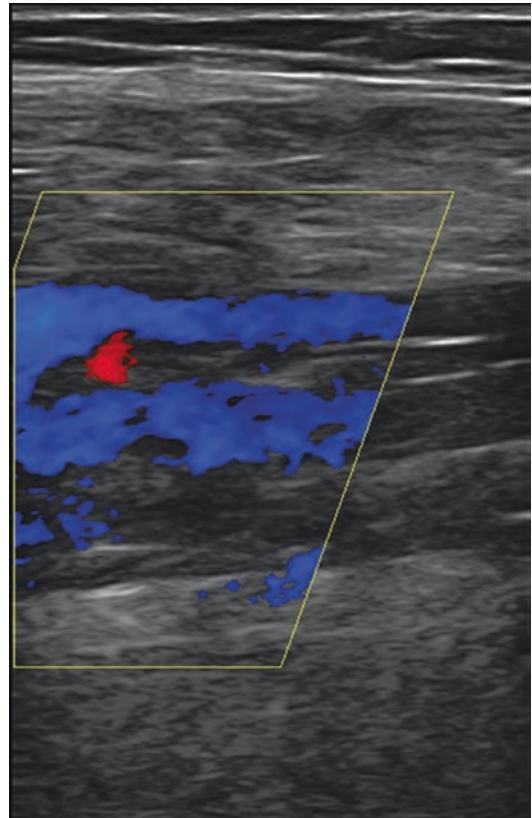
This 41-year-old man underwent transverse ultrasonography of the paired posterior tibial veins 2 weeks before liposuction of the trunk, subcutaneous mastectomies for gynecomastia, and a submental lipectomy. Images depict the patient before (*left*) and after
